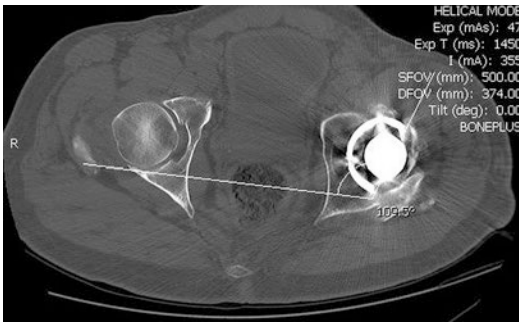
CT scan of the pelvis of a patient demonstrating 19.5° of acetabular retroversion
